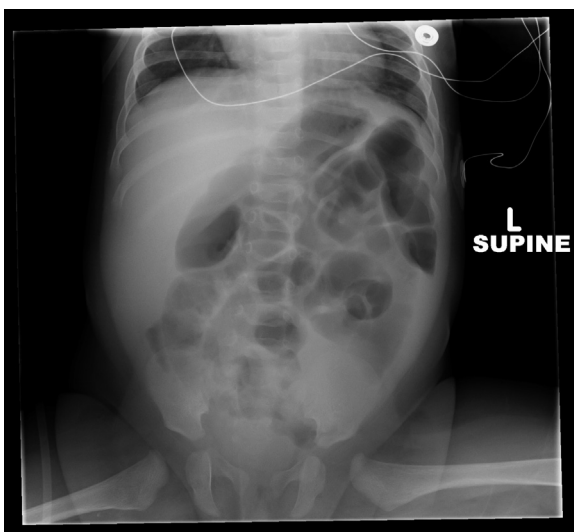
Abdominal x-ray study showing mild gaseous distension of multiple bowel loops.
